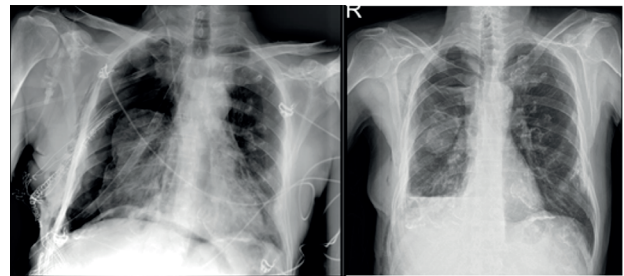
Postoperative 0th day chest X-ray and chest X-ray after chest tube removal.
